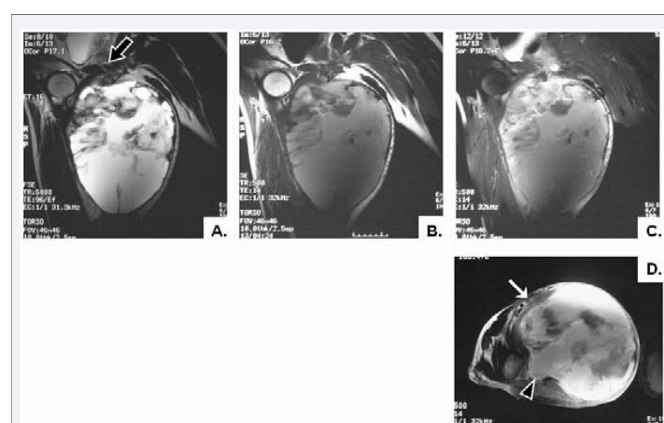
Coronal MR images showed a massive lesion with high signal intensity on T2-weighted imaging (A), faintly high intensity on T1-weighted imaging (B), and partially peripheral enhancement on fat-suppressed T1-weighted imaging after gadolinium injection (C). The mass contained nodules and septa indicating a loculated tumor and it contacted the obturator foramen (thick arrow). D. Axial, fat-suppressed T1-weighted image demonstrated the lesion contacted the lesser trochanter and was close to the femoral artery (thin arrow) and sciatic nerve (arrowhead).
